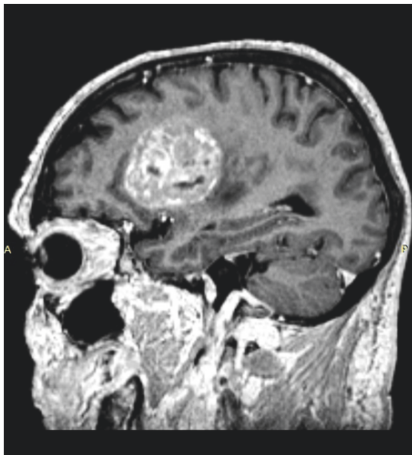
Sagittal T1-weighted postcontrast MR images of a patient with HGG used for RTP.
